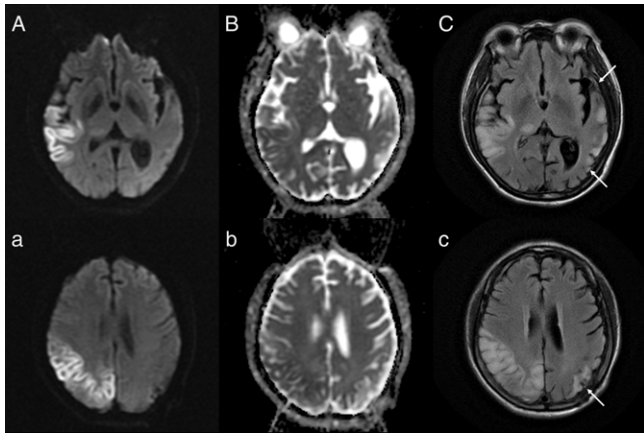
Axial brain magnetic resonance imaging during second stroke-like episode. Diffusion-weighted imaging (A,a) shows cortical hyperintensity now involving the right temporal, parietal, and occipital lobes with cortical restricted diffusion on apparent diffusion coefficient map (B,b). T2-Fluid attenuated inversion recovery sequences (C,c) shows cortical hyperintensity in those areas, with atrophy and residual hyperintensity in the left temporal and occipital cortex (arrows).
